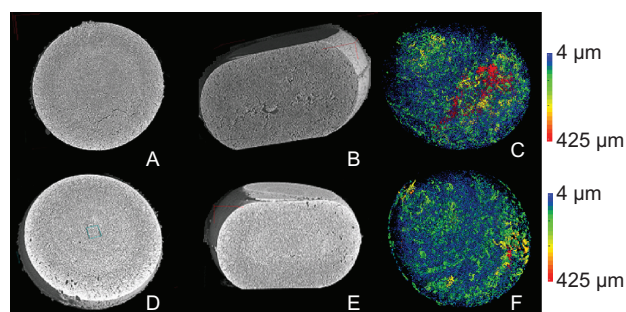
Reconstructed CT scans of an injection-molded tablet composed of 30/35/35% MPT/EC/PEO 7×10^6 processed at 120°C (A–C) and 140°C (D–F) with A and C being longitudinal trans-sections and B and D transversal cross-sections. C and F represent the equivalent diameter distribution of the pores.
